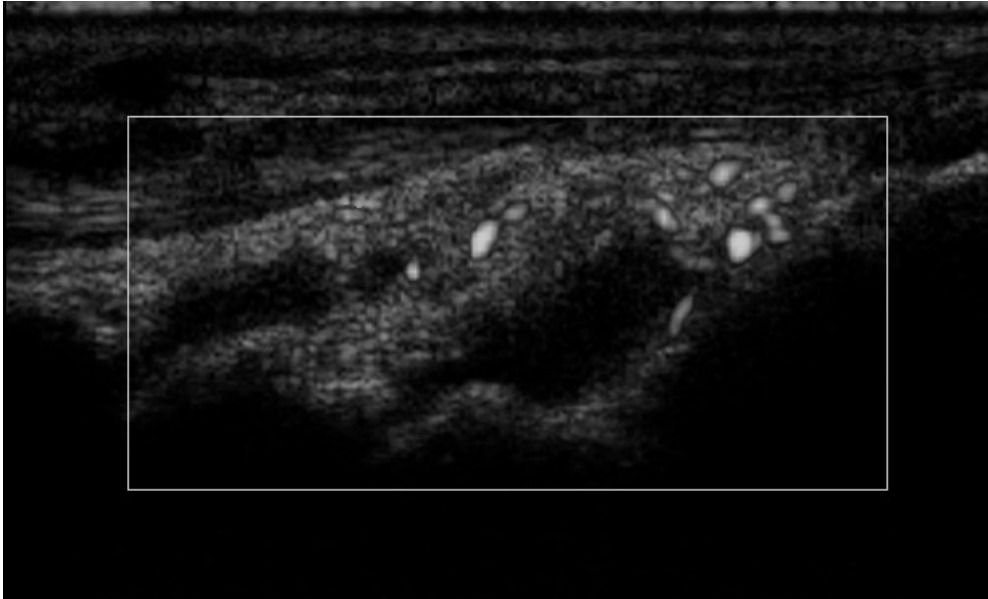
Longitudinal view of a wrist, with synovitis, effusion and increased Power Doppler signals.
